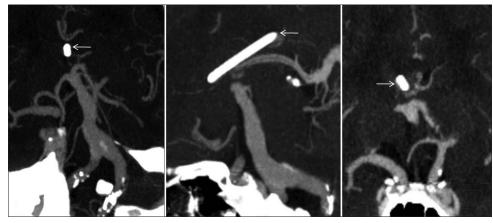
CT angiogram performed 3 months after placement of VP shunt (arrow). Vertebrobasilar arteries are dolichoectatic. Calcifications can be seen in bilateral vertebral arterial walls. Basilar artery is seen bifurcating much above the suprasellar region and approximating the floor of the third ventricle to its roof. VP shunt (arrow) is seen with its tip in the frontal horn of the right lateral ventricle
